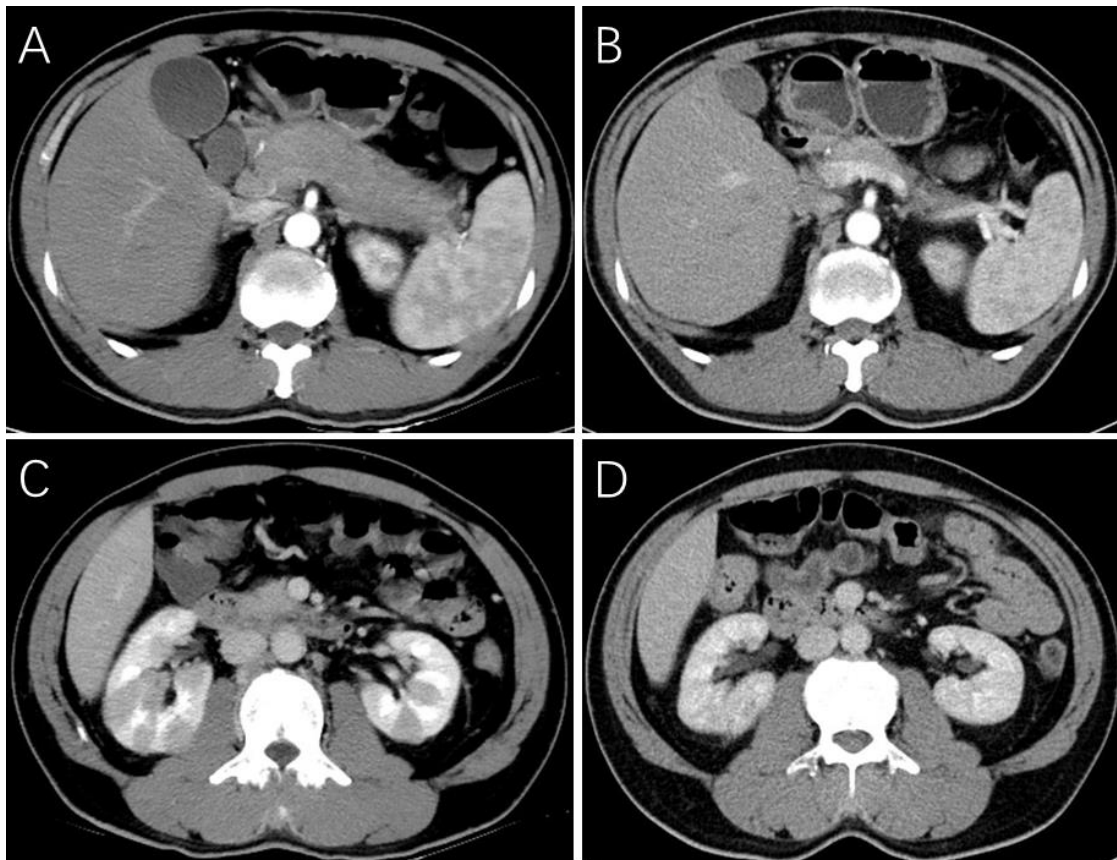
Contrast-enhanced abdominal computed tomography detecting characteristic sausage-like pancreas with a capsule-like low-density rim (A) and diffuse masses lacking of perfusion in bilateral kidneys (C), and significant improvement after hormonal therapy (B and D).
